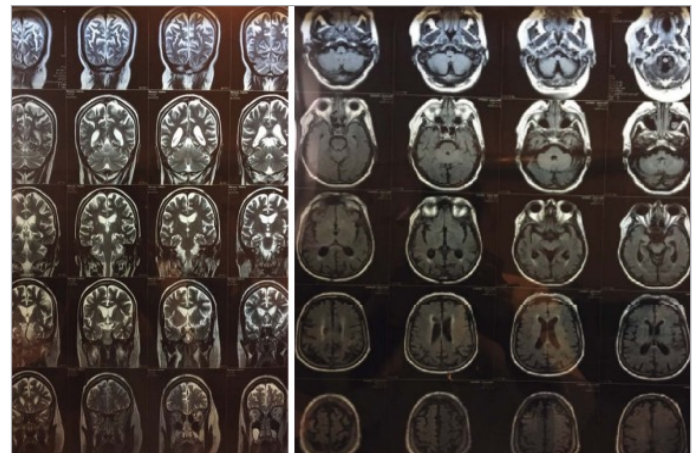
Magnetic resonance imaging shows compatible alterations.
